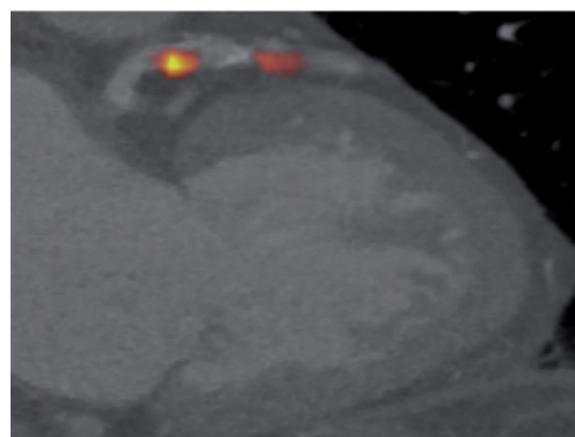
PET/CT images of the coronary artery following administration of 18F-NaF. Regions of novel or micro-calcification are again shown in yellow/red and are seen in a region of mixed non-obstructive coronary plaque in the proximal left anterior descending artery.
